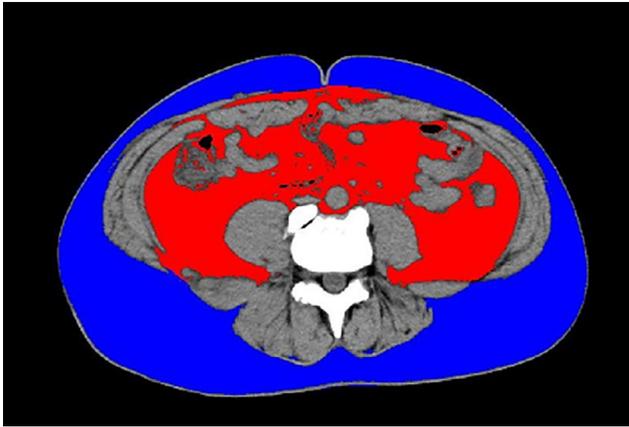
Computed tomographic image of the visceral adipose area (red) and subcutaneous fat area (blue) at the level of the navel.
